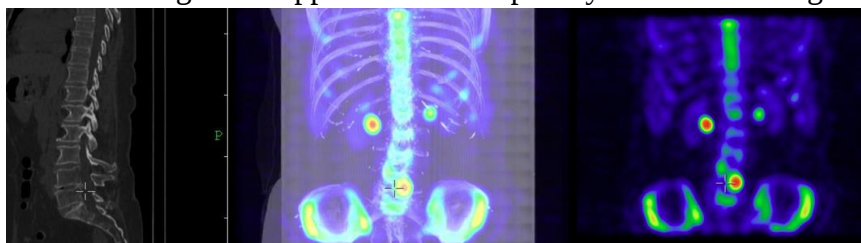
SPECT/CT bone imaging showing focal pathological radiotracer accumulation at L5, with fused anatomical and functional imaging enabling precise lesion localization.
